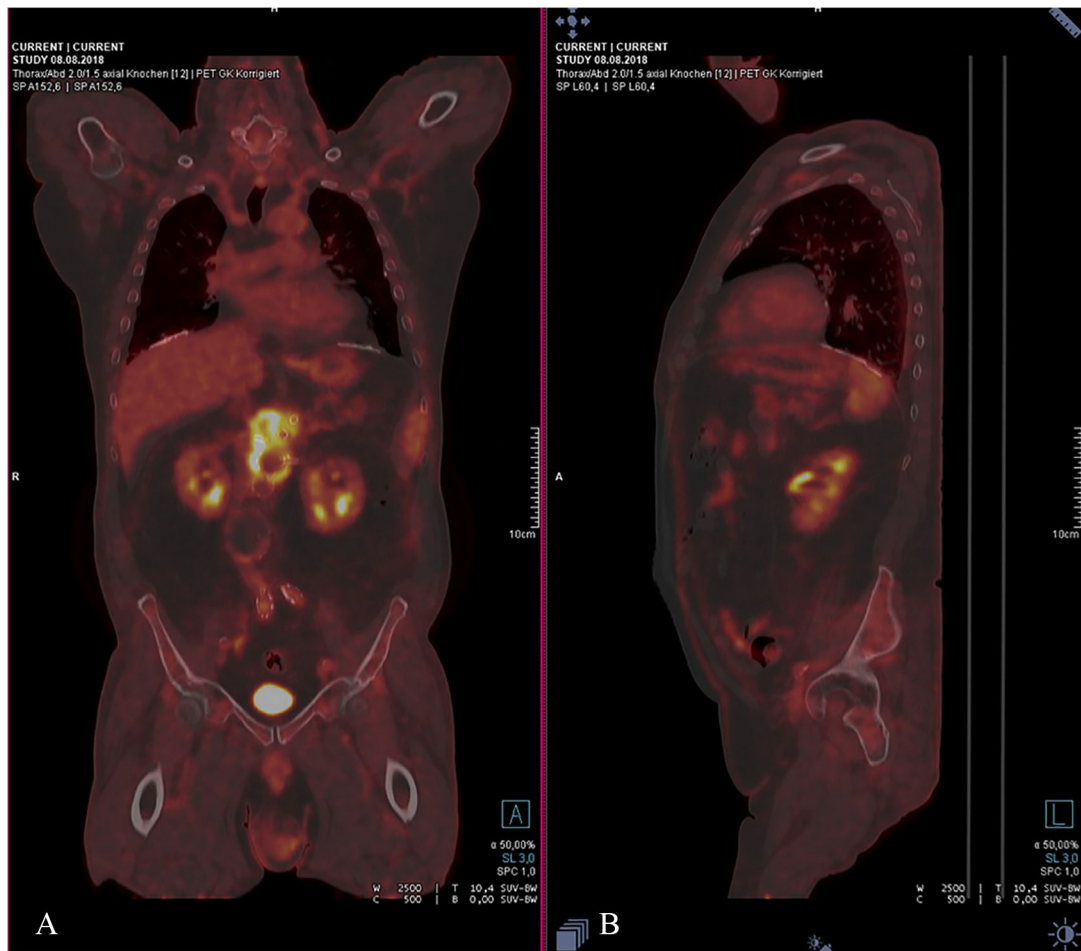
Fludeoxyglucose (^{18}F) positron emission tomography computed tomography shows enhancement of tracer around the graft in the abdominal aorta in the (A) coronal and (B) sagittal plane.
